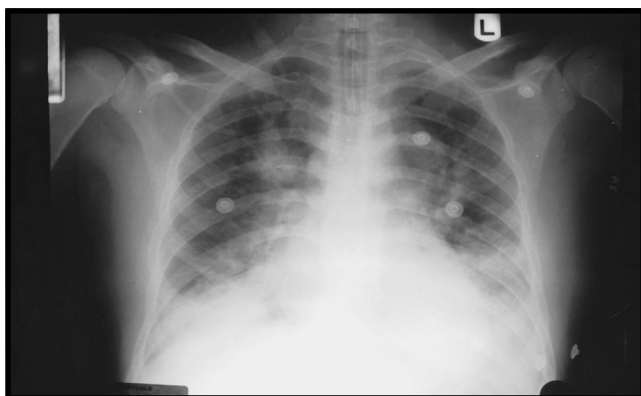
Chest radiograph after intubation showed significant increase in the alveolar infiltrates and bilateral pleural effusion.
